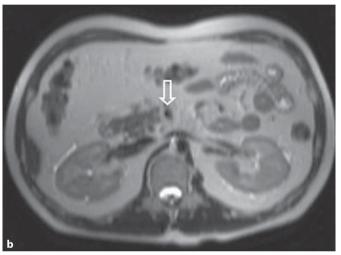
Follow-up T_2 -weighted axial abdominal MRI scan at the levels corresponding to those mentioned in figure 1 obtained on day 165. Total regression of the thrombosis in the portal vein (white arrow) and superior mesenteric vein (open arrow).
